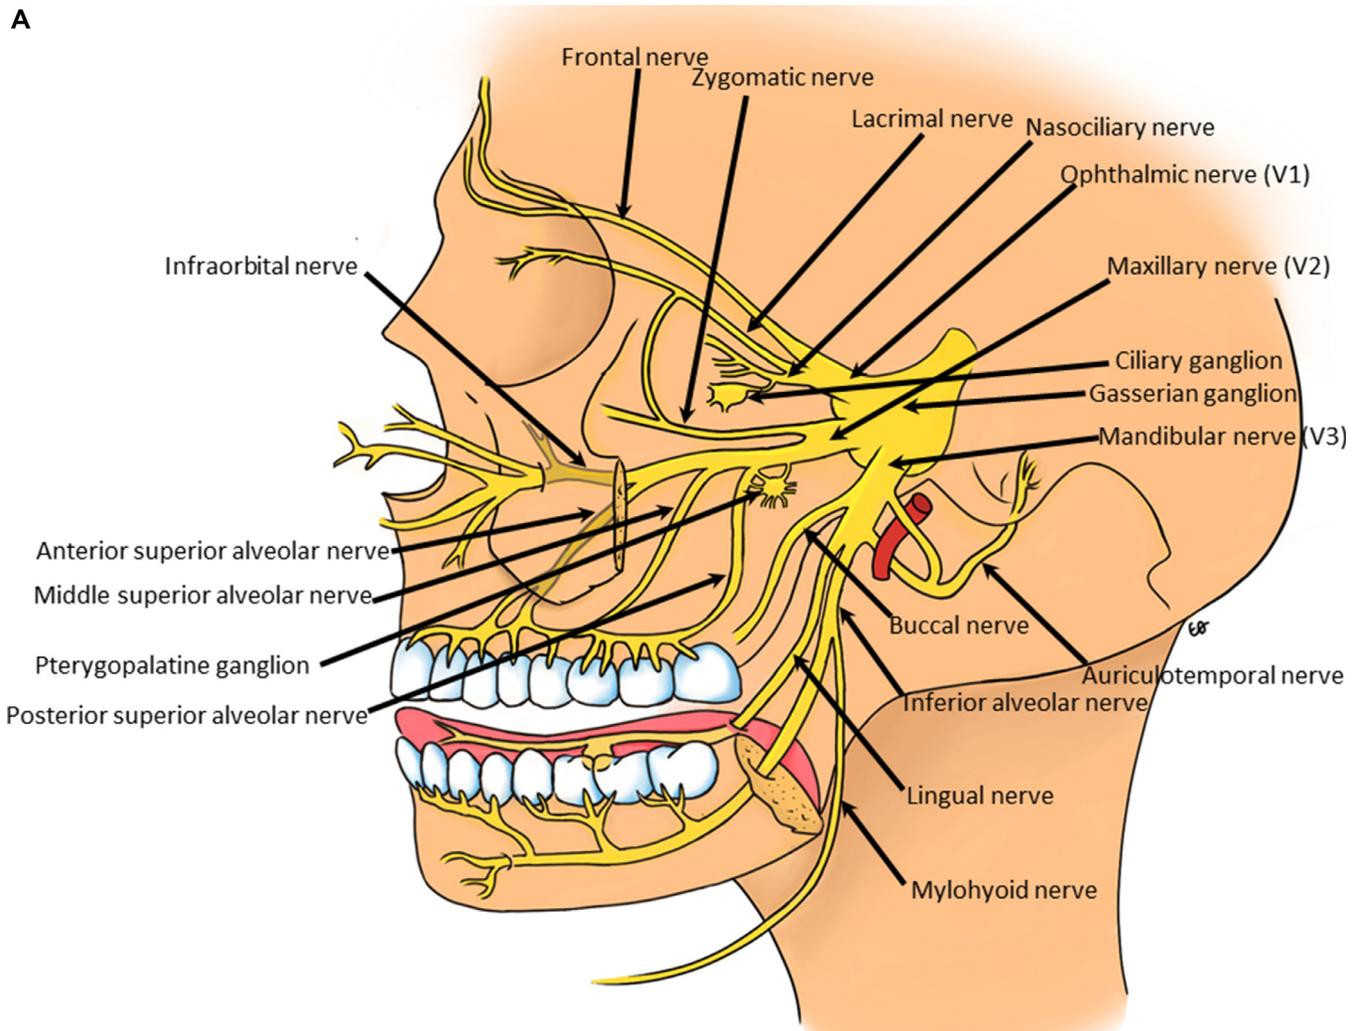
(A) The 3 divisions of the fifth nerve separate within the trigeminal cave. The V1 and V2 divisions are sensory and transit the lateral wall of the cavernous sinus. V1 divides into the lacrimal, frontal and nasociliary branches before entering the orbit through the superior orbital fissure. V2 enters foramen rotundum then transits the pterygopalatine fossa where it gives off the zygomatic nerve, 2 sphenopalatine branches and superior alveolar branches. V3 has sensory and motor components and exits the skull base via foramen ovale, dividing into an anterior primarily motor trunk supplying the muscles of mastication. The dominant primarily sensory posterior trunk branches shown in the figure are more susceptible to perineural tumor spread and include the auriculotemporal, inferior alveolar, and lingual nerves. The auriculotemporal nerve is another area of communication between the trigeminal and facial nerves. (B) V2 or the maxillary nerve enters the pterygopalatine fossa and continues anteriorly as the infraorbital nerve. The greater and lesser palatine nerves extend caudally from the pterygopalatine fossa toward the palate. The greater superficial petrosal nerve exits the facial nerve near the geniculate fossa at the facial hiatus and joins the deep petrosal nerve to form the vidian nerve which enters the pterygopalatine fossa, serving as one of the key communications between the 5th and 7th nerves. (C) Coronal CT reformat without contrast. V2 exits the skull base through foramen rotundum (white arrow), seen as a round foramen just superior to the pterygoid process laterally. The vidian canal (black arrow) through which the vidian nerve transits is medial to foramen rotundum. These foramina should be routinely assessed as part of a search pattern when evaluating for perineural tumor spread. (D) and (E) axial CT without contrast. (D) The foramen rotundum (white arrow) is tubular in the axial plane and anteriorly extends to the superior margin of the pterygopalatine fossa (white asterisk), where V2 then courses anteriorly into the inferior orbital fissure (white arrowhead) as it courses toward the infraorbital nerve canal. (E) Foramen ovale (white arrowhead), through which V3 passes as it extends into the infratemporal fossa is oval shaped in the axial plane and seen parallel and lateral to foramen lacerum (black asterisk). The vidian canal (white arrow) is tubular in the axial plane, extending from the anterior margin of foramen lacerum to communicate with the pterygopalatine fossa (white asterisk). (F) Coronal CT reformat without contrast. In the coronal plane, foramen ovale (black asterisk) is normally seen as a discontinuity in the floor of the middle cranial fossa. (G) Axial and (H) coronal T1-weighted postcontrast fat-saturated image shows normal venous enhancement surrounding V3 within the foramen ovale (white arrows).
